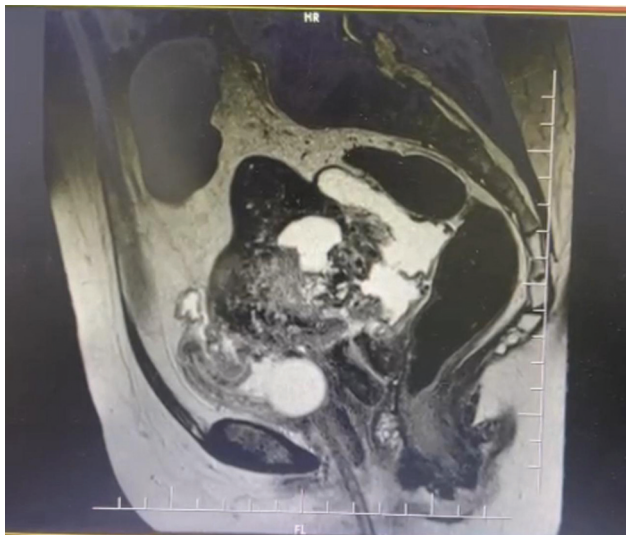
Magnetic resonance imaging showing pelvic mass infiltrating the bladder.
